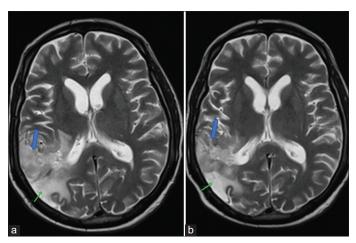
(a) Pre-treatment axial T2-weighted image showing the tumor (blue arrow) with surrounding edema (green arrow); (b) Post-treatment (day 20) axial T2-weighted image showing reduction in the tumor size (blue arrow) as well as the perilesional edema (green arrow)
